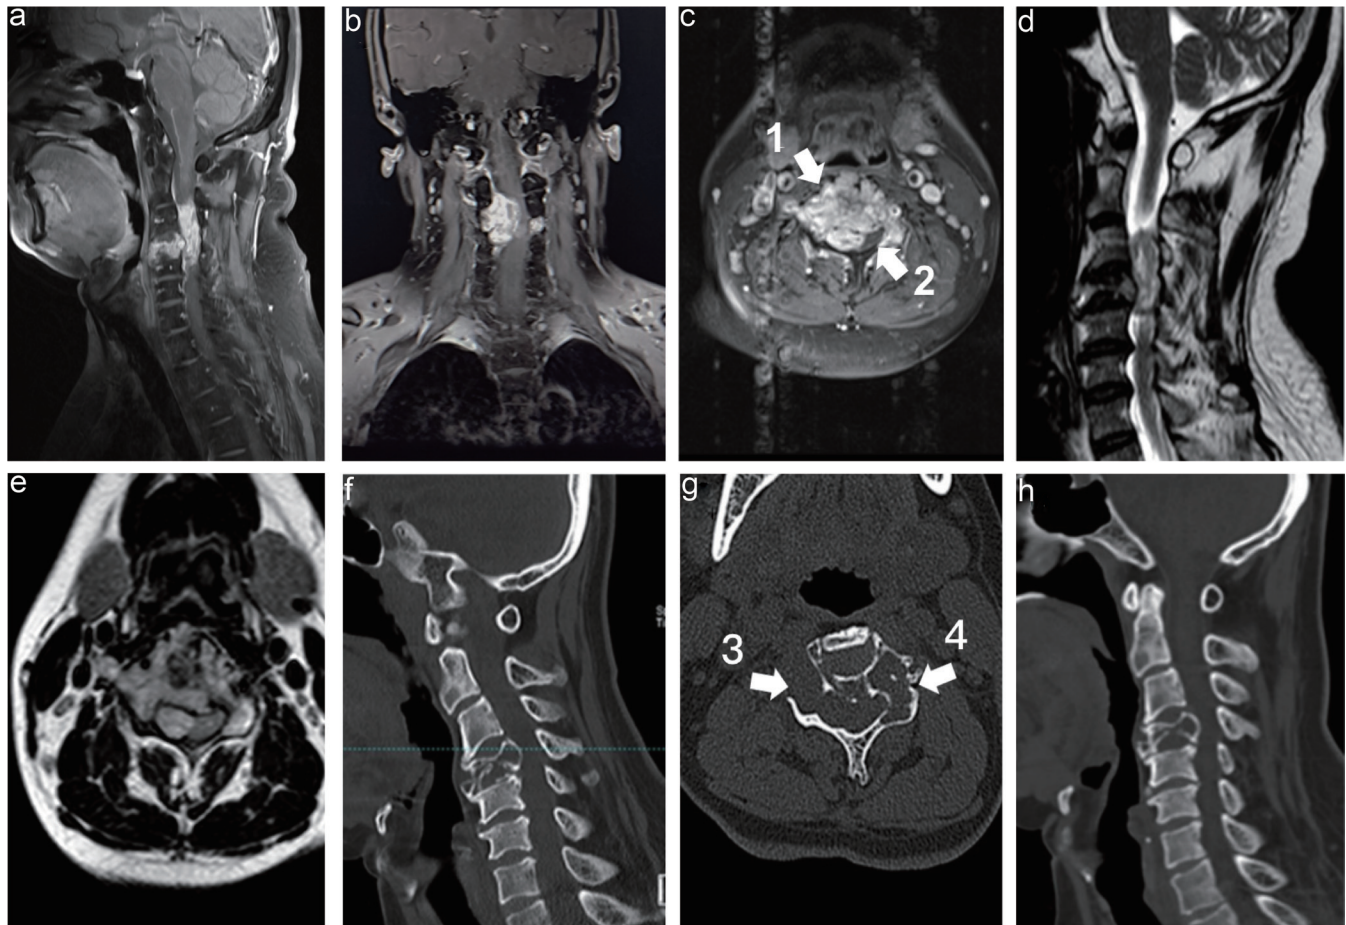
Preoperative cervical MRI and CT. Preoperative sagittal (a) and coronal (b) enhanced T1-weighted MRI showed a giant invasive spinal tumor at the C3-5 level. Axial enhanced T1-weighted MRI (c) revealed the tumor with spinal cord compression extended bilaterally across the C3-4 extraforaminal region, surrounded the spinal cord in a “U”-like shape, and invaded the C4 vertebral body (c, arrow 1) and pedicles (c, arrow 2). Compared to the sagittal and axial T2-weighted MRI (d, e) performed in the outside hospital a year ago, the tumor was not enlarged. Preoperative sagittal CT (f) showed C4 vertebral body collapse and soft tissue density in the cancellous substance of C4. Axial CT (g) revealed the tumor eroded bilateral pedicles (g, arrow 3 and 4). Compared to the sagittal CT (h) performed in the outside hospital, it was determined that the C4 vertebral body collapse occurred a year ago. CT, computed tomography; MRI, magnetic resonance image.
